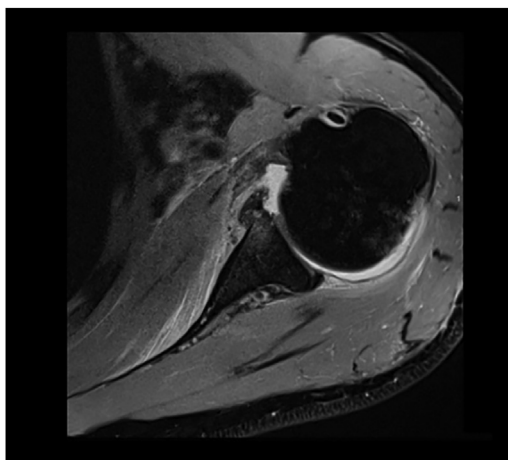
Noncontrast MRI of the injured shoulder demonstrating bony Bankart lesion. MRI, magnetic resonance imaging.
